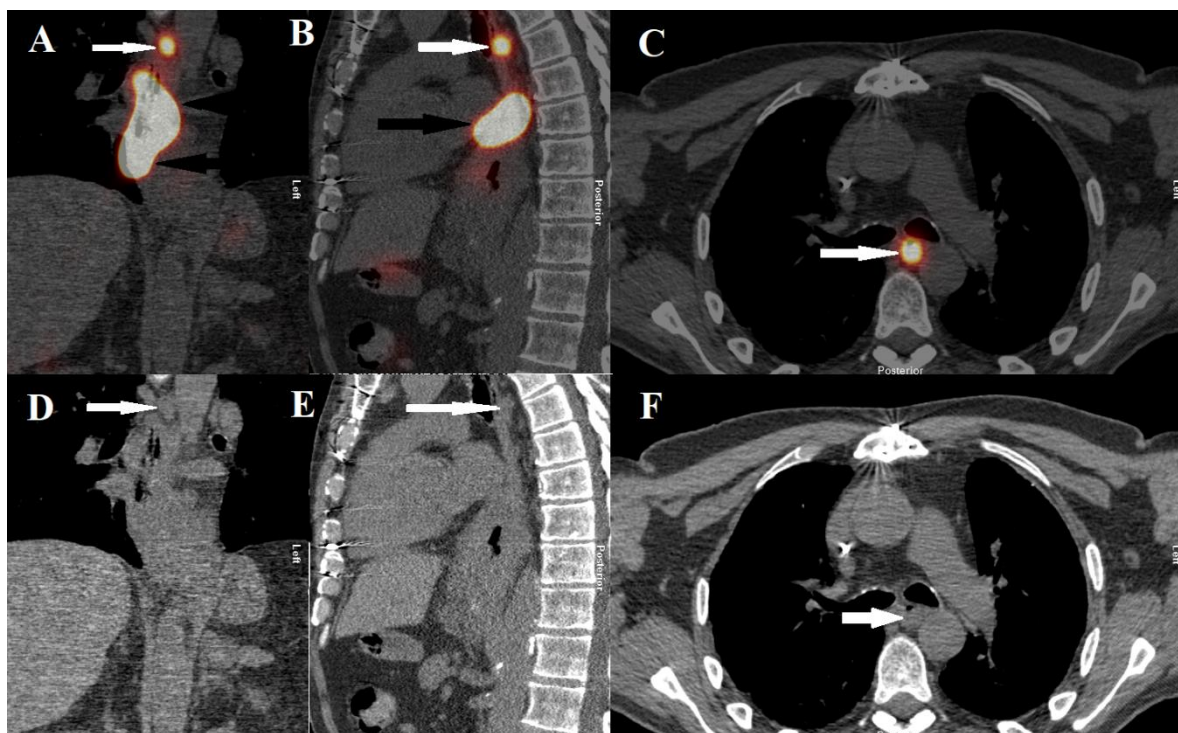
SPECT/CT lymphoscintigraphy images of a 65-year-old male patient with a T3N2M0 adenocarcinoma of the distal oesophagus and GOJ (Siewert 2) undergoing pre-operative SLN mapping. Images A-C consist of Hybrid SPECT/CT images in coronal, sagittal and transversal orientations. Images D-F are of CT images in an unfused state in the same orientations. White arrows indicate radiocolloid uptake in, and the anatomical location of a Sentinel Lymph Node located in the mediastinum, in the 101L lymph node station (as defined by the Japanese Classification of Oesophageal Cancer, 11th Edition). Black arrows indicate radiocolloid deposit in one of the intra-/peritumoural injection sites.
